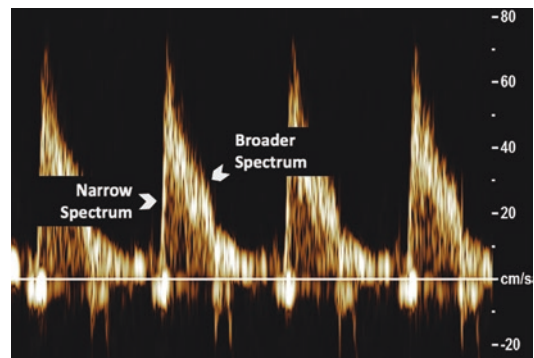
Spectral narrowing. Doppler waveforms from the pulmonary artery demonstrating very narrow spectrum during the early systolic phase with blood flowing in relatively uniform velocity, which becomes broader in the diastolic phase
